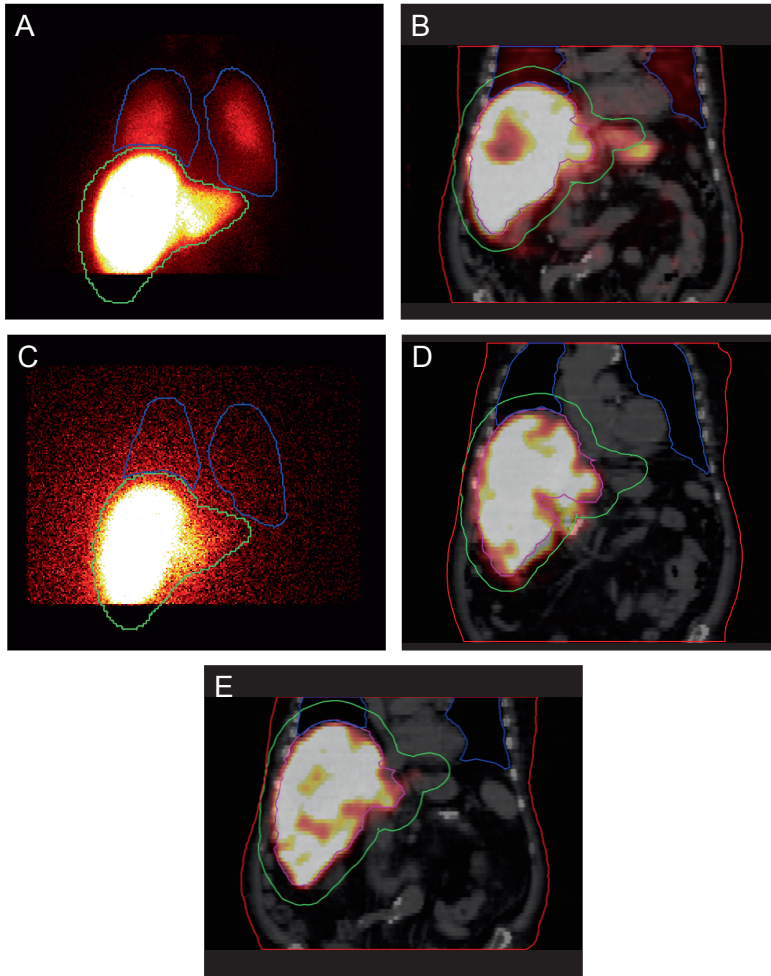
Scintigraphic and SPECT images of patient 1. The GM image of the ^{99m}Tc -MAA scout dose (A), a coronal slice through the SPECT image of the ^{99m}Tc -MAA scout dose (B), the GM image of the ^{166}Ho -MS scout dose (C), a coronal slice through the SPECT image of ^{166}Ho -MS scout dose (D), and a coronal slice through the SPECT image of the ^{166}Ho -MS treatment dose (E). GM images are overlaid with the boundaries of $\text{ROI}_{2\text{D-LIV}2\text{CM}}$ (A,C; green) and $\text{ROI}_{2\text{D-LUNG}}$ (A,C; blue). SPECT images are fused with CT and overlaid with the boundaries of $\text{ROI}_{3\text{D-LIV}2\text{CM}}$ (B,D,E; green), $\text{ROI}_{3\text{D-RL}}$ and $\text{ROI}_{3\text{D-LL}}$ (B,D,E; blue), $\text{ROI}_{3\text{D-LIV}}$ (B,D,E; pink) and $\text{ROI}_{3\text{D-WB}}$ (B,D,E; red). A homogeneous distribution of ^{99m}Tc -MAA in the lung region is clearly observed in (B), whereas this is not the case for ^{166}Ho -MS in (D) and (E).
